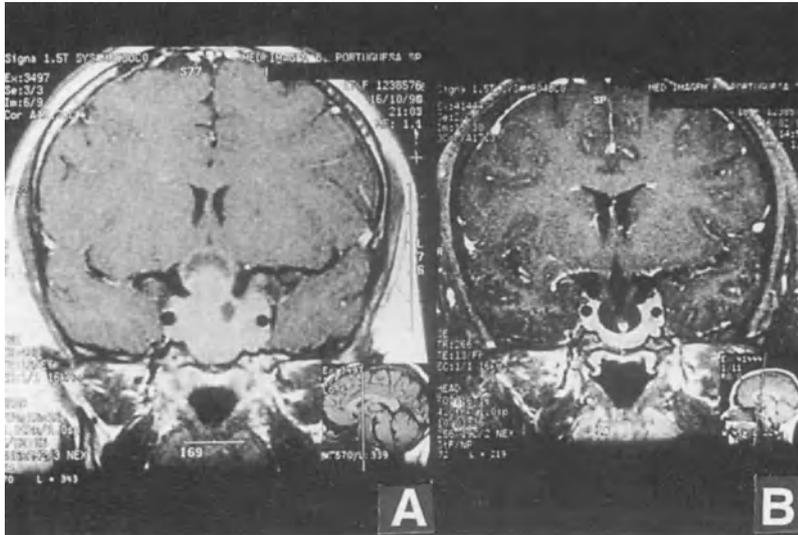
Macroprolactinoma treated by bromocriptine. Coronal view of MRI (T1 weighted). (A) Before treatment: showing an huge invasive macroprolactinoma with suprasellar and parasellar extensions and sphenoid sinus invasion. (B) During treatment: note near complete disappearance of tumor mass with secondary empty sella.
